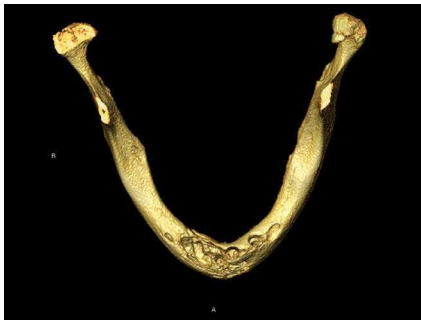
Computed tomography (axial slices and 3D reconstruction), revealing absence of implants and severe destruction of mandibular symphysis bone.
